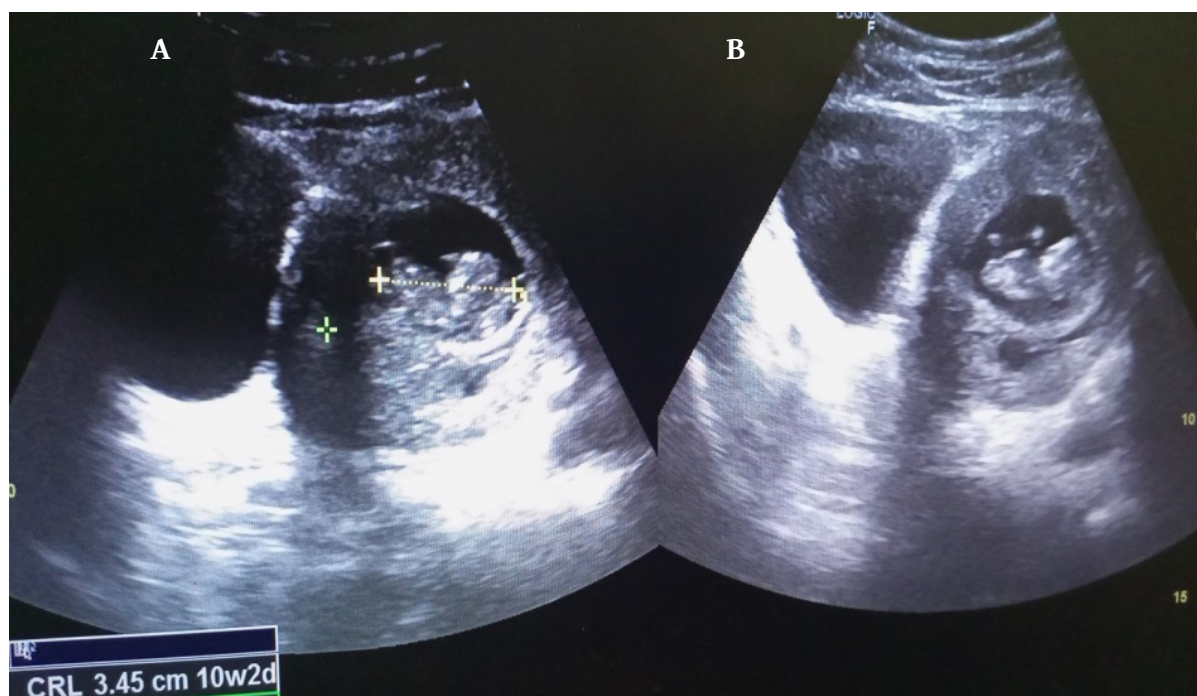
Static grey scale sonogram showing a gravid uterus harboring a singleton fetus in transverse position in a 16 year old teenager (A) the CRL measurement of the fetus (B)
